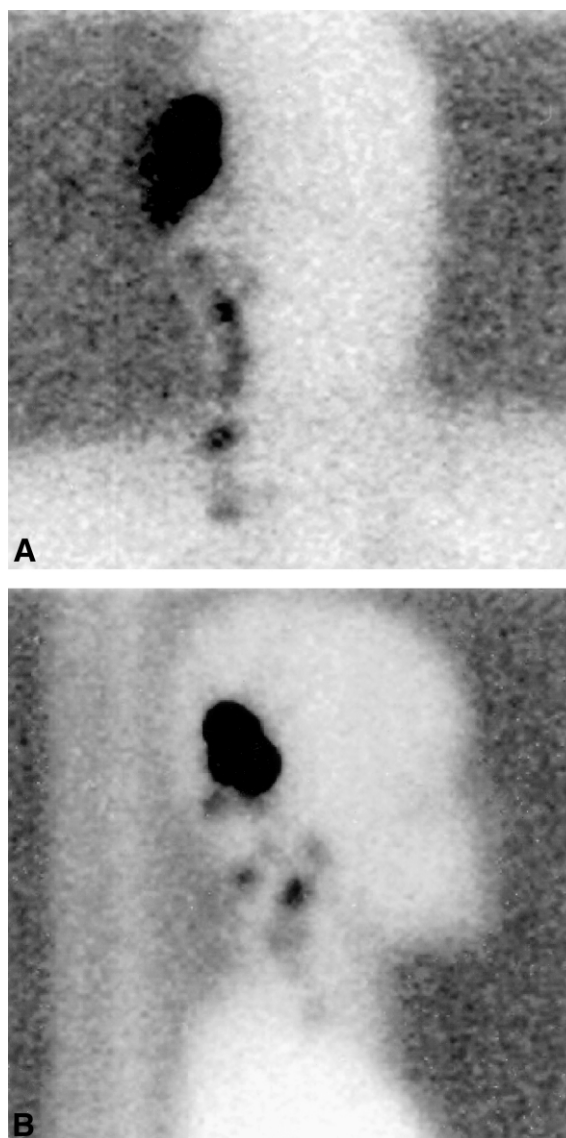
Preoperative radiolymphoscintigrams demonstrating multiple sentinel lymph nodes: (A) anterior–posterior view, (B) lateral view.
